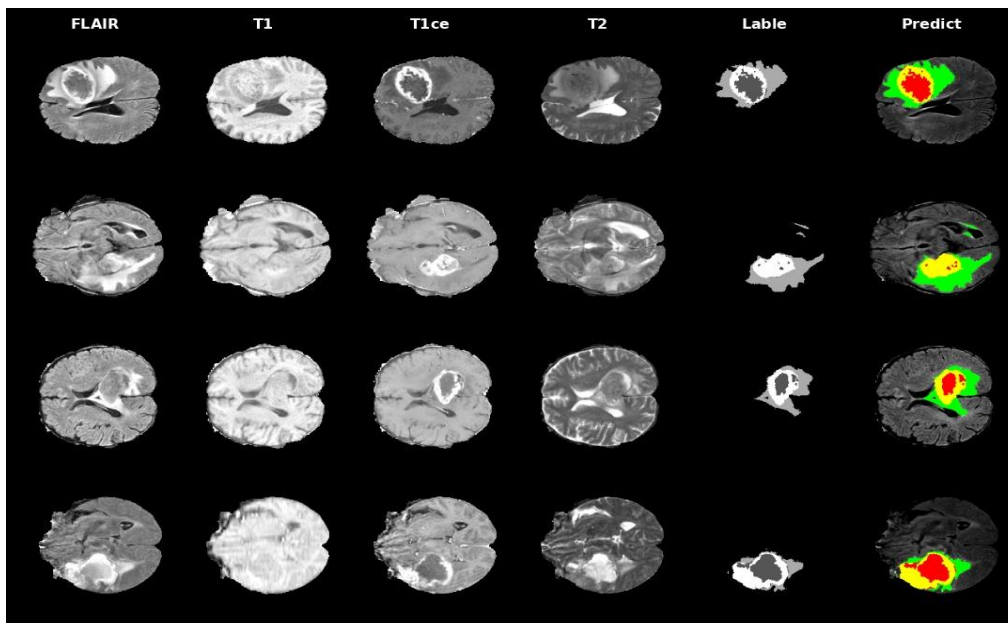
The 5-fold cross-validation results for axial views on a multi-model MRI dataset.
